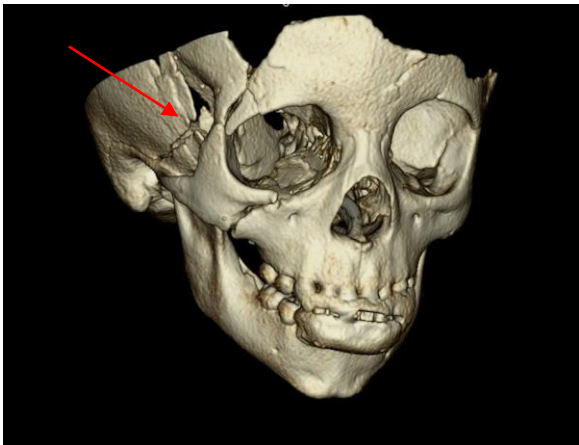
3D CT Render of Skull Fractures
